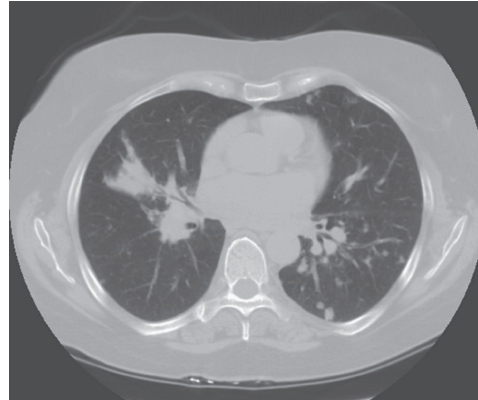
High-resolution CT scan of the chest demonstrating patchy reticular nodularity, including areas of confluence.
